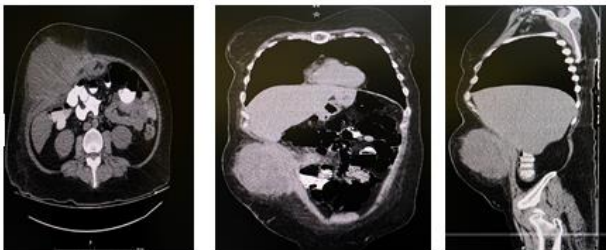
Computed tomography image in which a tumor is observed in the abdominal wall suggestive of an abscess.
